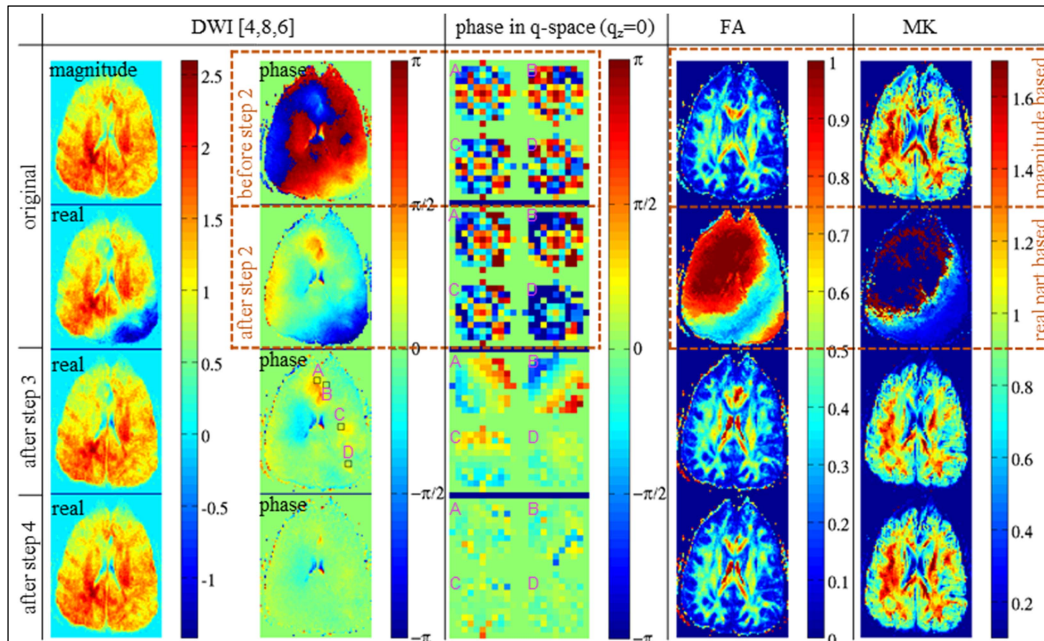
DWI (col. 1&2), phase maps in  $q$ -space ( $q_x$ - $q_y$ -plane) for four example image pixels (col. 3) for different steps in the data processing (rows 1-4). FA (col. 4) and MK (col. 5) using the magnitude data (row 1) and using the real part of the data after the corresponding processing steps (rows 2-4).
